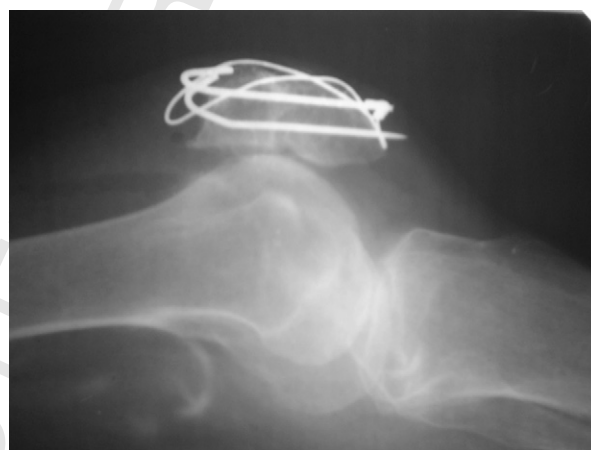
Postoperative radiograph showing features of union (lateral view).
